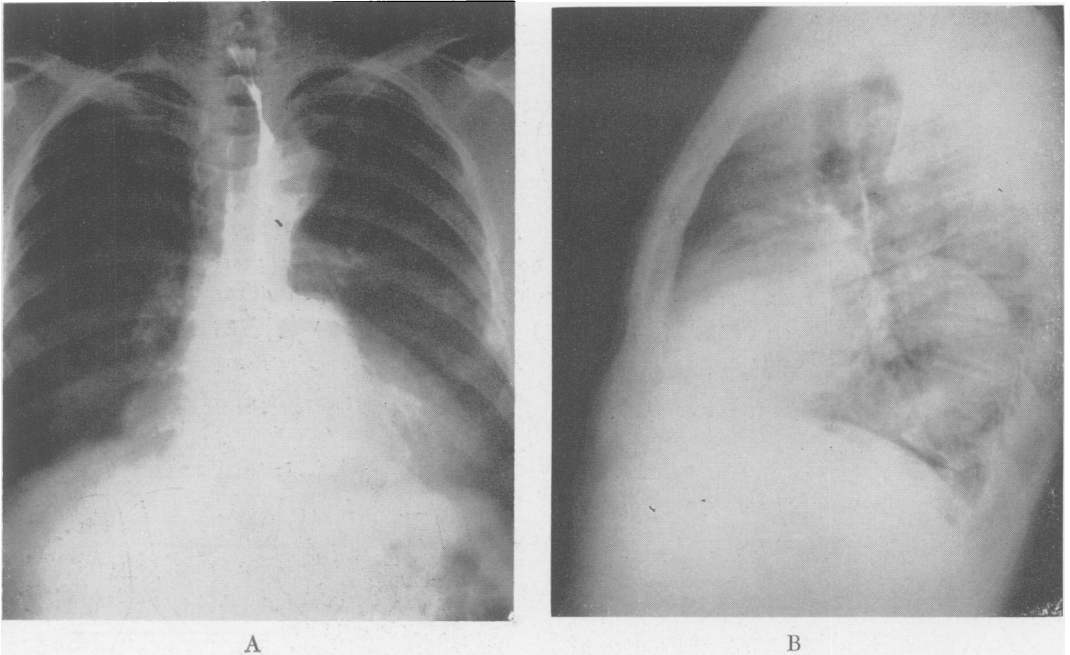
A and B. Roentgenograms of chest in Case 1 in postero-anterior and lateral projections, showing tortuous, dilated descending thoracic aorta extending into left paravertebral sulcus.
